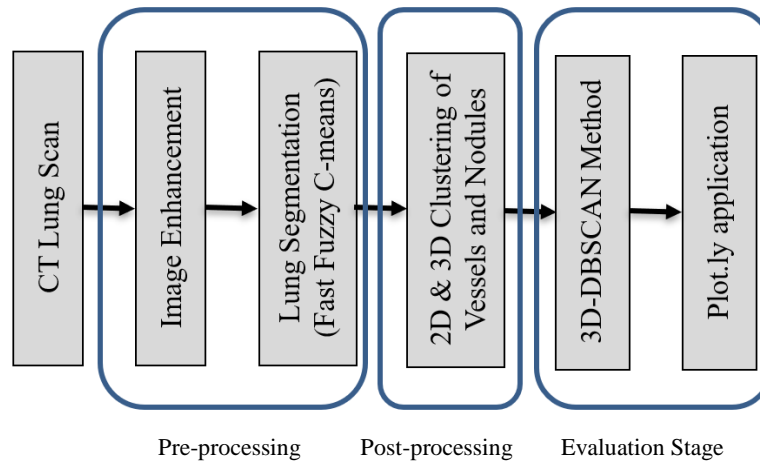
The Proposed Model of Lung CT scan Clustering
